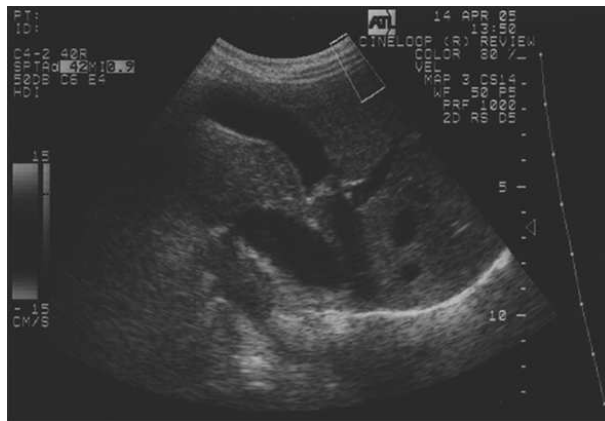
Original ultrasound image of the normal gall-bladder
